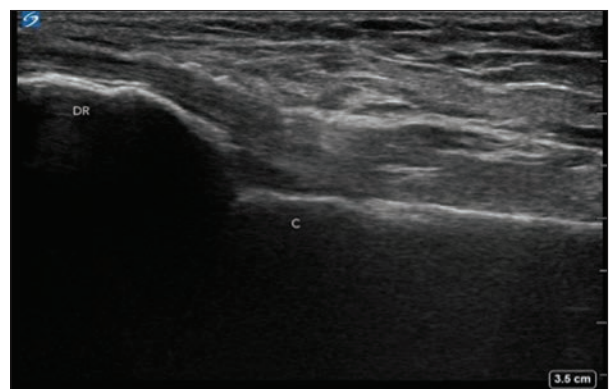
Point-of-care ultrasound image of distal radius fracture reduction (longitudinal view) demonstrating reduction of angulation. DR: Distal radius, C: Cortex.
